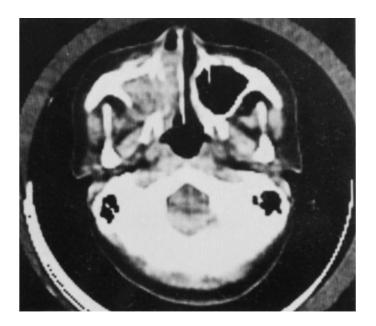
CT of Case 7 showing bone defects of the posterior-lateral wall of the right maxillary sinus. Total maxillectomy performed after ⁶⁰Co irradiation (6000 rad (60 Gy)) revealed no bone defects of that wall.
